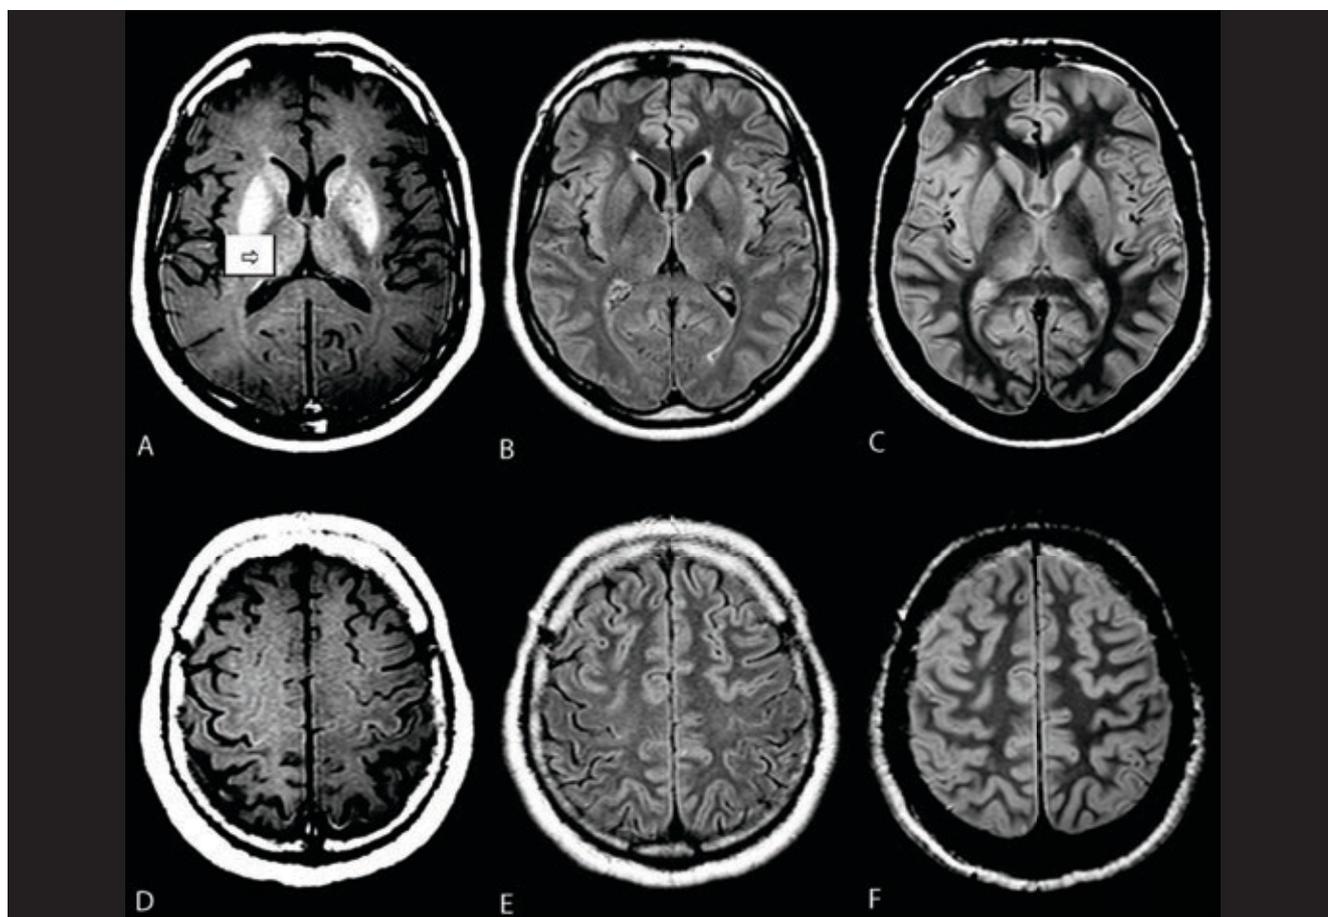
Asymmetric ALS (32-year-old man). (A) A small, ovoid hyperintensity in the CST in the right internal capsule (arrow) is only noticed on axial T1 SE MTC. Axial FLAIR (B) and PDWI (C) images are unremarkable. The faint hyperintensity on FLAIR is usually noted in healthy individuals. Comparative images in the subcortical regions of the precentral gyri also demonstrate hyperintensity on T1 SE MTC (D), not restricted to the CST. FLAIR (E) and PDWI (F) results are completely normal.
